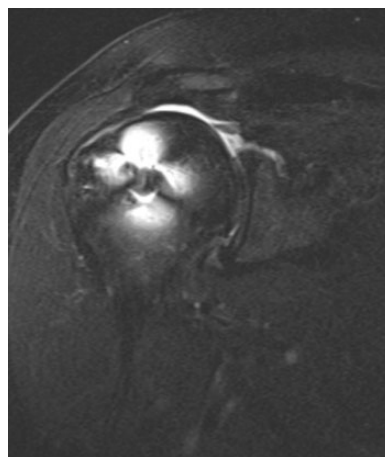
This postoperative magnetic resonance coronal T2-weighted image demonstrates a repair that is not intact.
